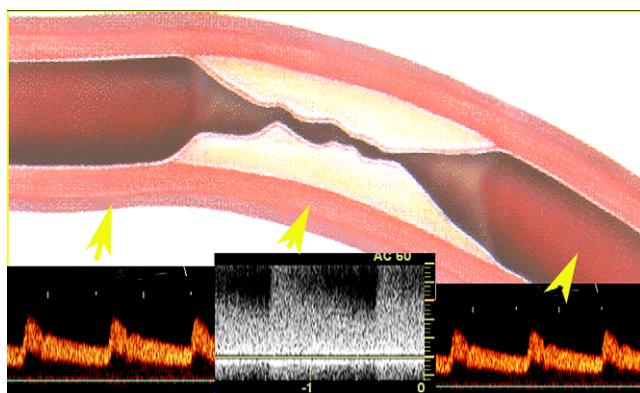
Direct hemodynamic effects of stenosis. The stenosis causes marked, violent acceleration of the flow. The Reynolds numbers in the stenotic segment are very high, and the laminar flow thus becomes turbulent, vorticose. The phenomena, which are well known in hydrodynamics, are reflected in the results of the Doppler spectral analysis. The spectral curve at the level of the stenosis displays violent systo-diastolic acceleration associated with marked spectral broadening. Upstream, the tracing is normal although the amplitude is reduced in cases of closed stenosis. Immediately downstream, the acceleration tends to diminish. In the separation zone, the stationary recirculation flow facilitates the development of thrombosis and the formation of post-stenotic dilatation (increased transmural pressure). Laminar flow is restored 1–2 cm downstream from the stenosis.
